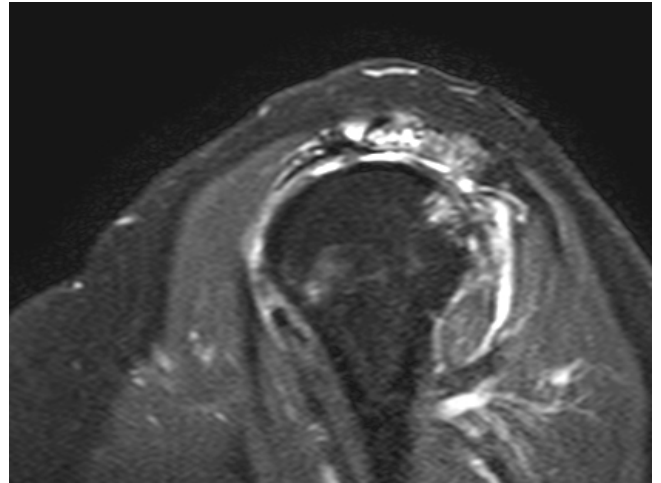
MRI images one year following SCR showing healed graft.
